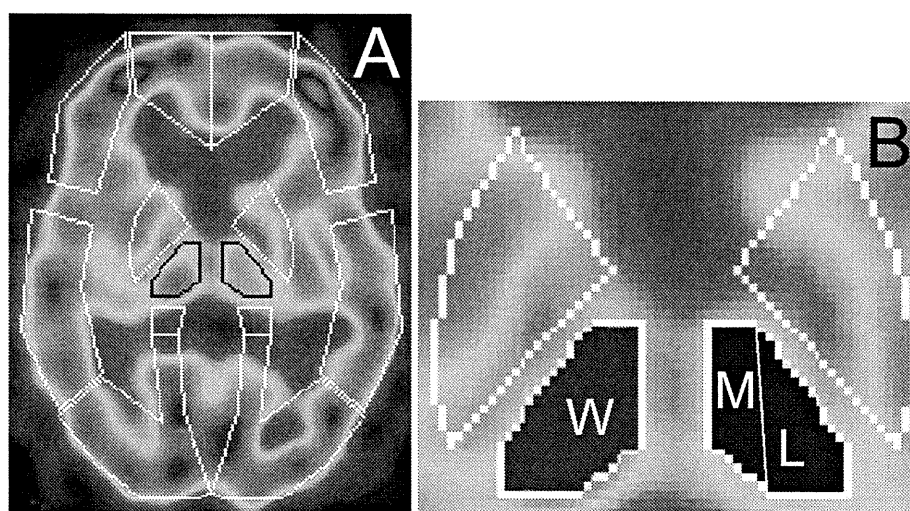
Standardized brain SPECT images showing presets of ROIs template of 3DSRT (A) and subdivisions of thalamus used for CTUI measurements (B). ROI over thalami is outlined in black. Whole thalamus is marked as (W), medial and lateral parts as (M) and (L) respectively.
